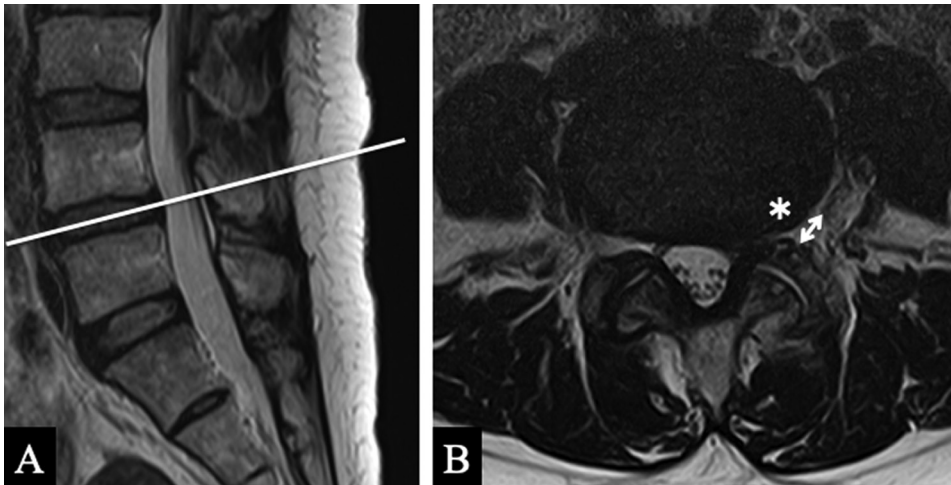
Measurement of the distance (*) between the superior articular process and the exiting nerve root using the axial view through the center of the disc space of the sagittal view on T2-weighted MRI. (A) Sagittal view. (B) Axial view. MRI: magnetic resonance imaging.
